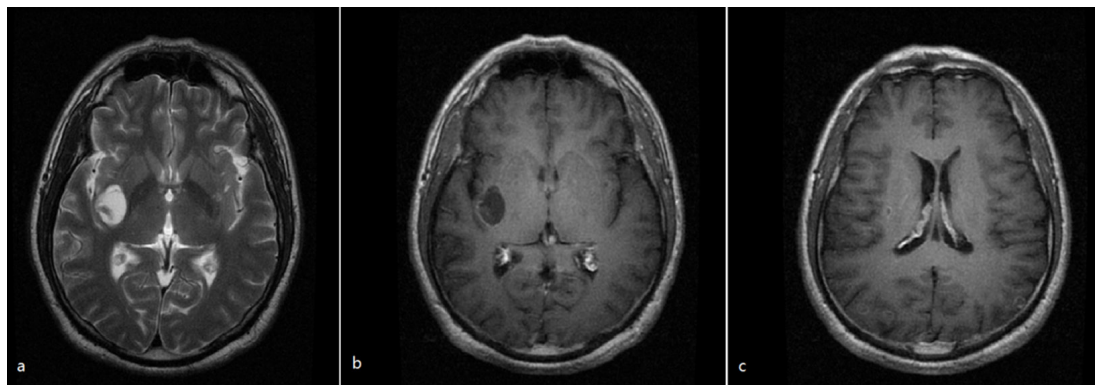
Magnetic resonance imaging (MRI) after 2 cycles of treatment with albendazole. (a) T2-MRI and gadolinium-enhanced MRI; (b) showed a single large cyst with cerebrospinal fluid-like signal in the right basal ganglia region; (c) gadolinium-enhanced MRI showed some ring-like or nodular contrast enhancements in occipital lobe
